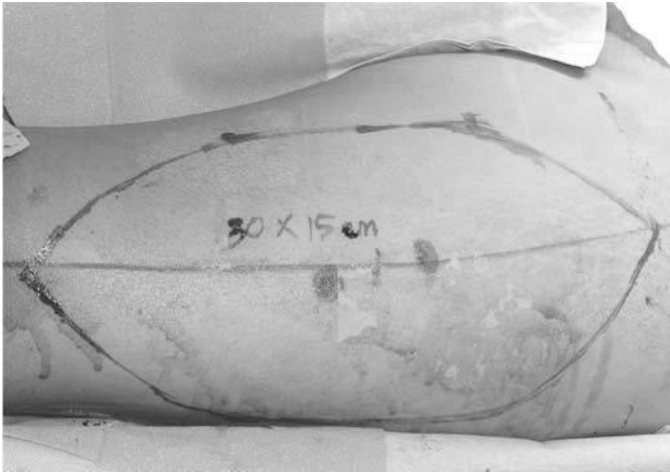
Flap Design. A 15 cm x 30 cm ALT flap design on the left thigh. Blue and red dots signify perforators identified using Doppler ultrasound.
